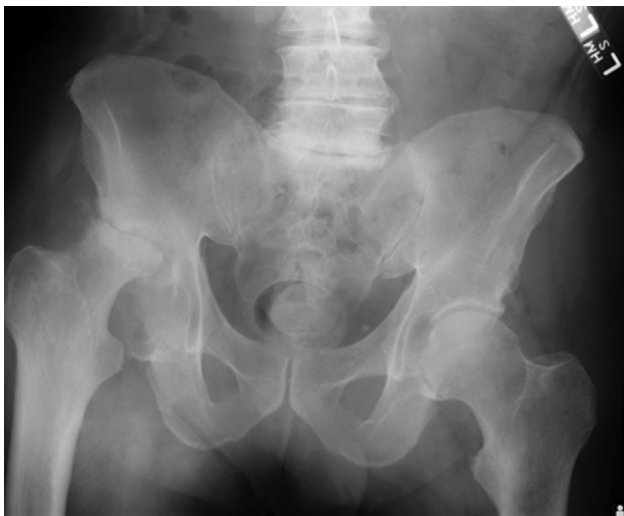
Preoperative anteroposterior pelvis radiograph of case 1 demonstrating avascular necrosis of the right femoral head with complete collapse, superolateral acetabular bone loss, and hip subluxation consistent with Paprosky 3A defect.
